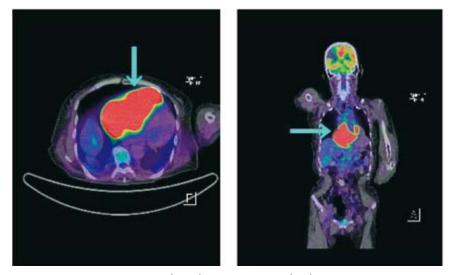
FDG-PET in coronal (right) and transaxial (left) views before treatment. There was intense FDG uptake (red color area) in the giant mass in the right atrium. The blue arrow indicates the giant cardiac lymphoma in the right atrium.
